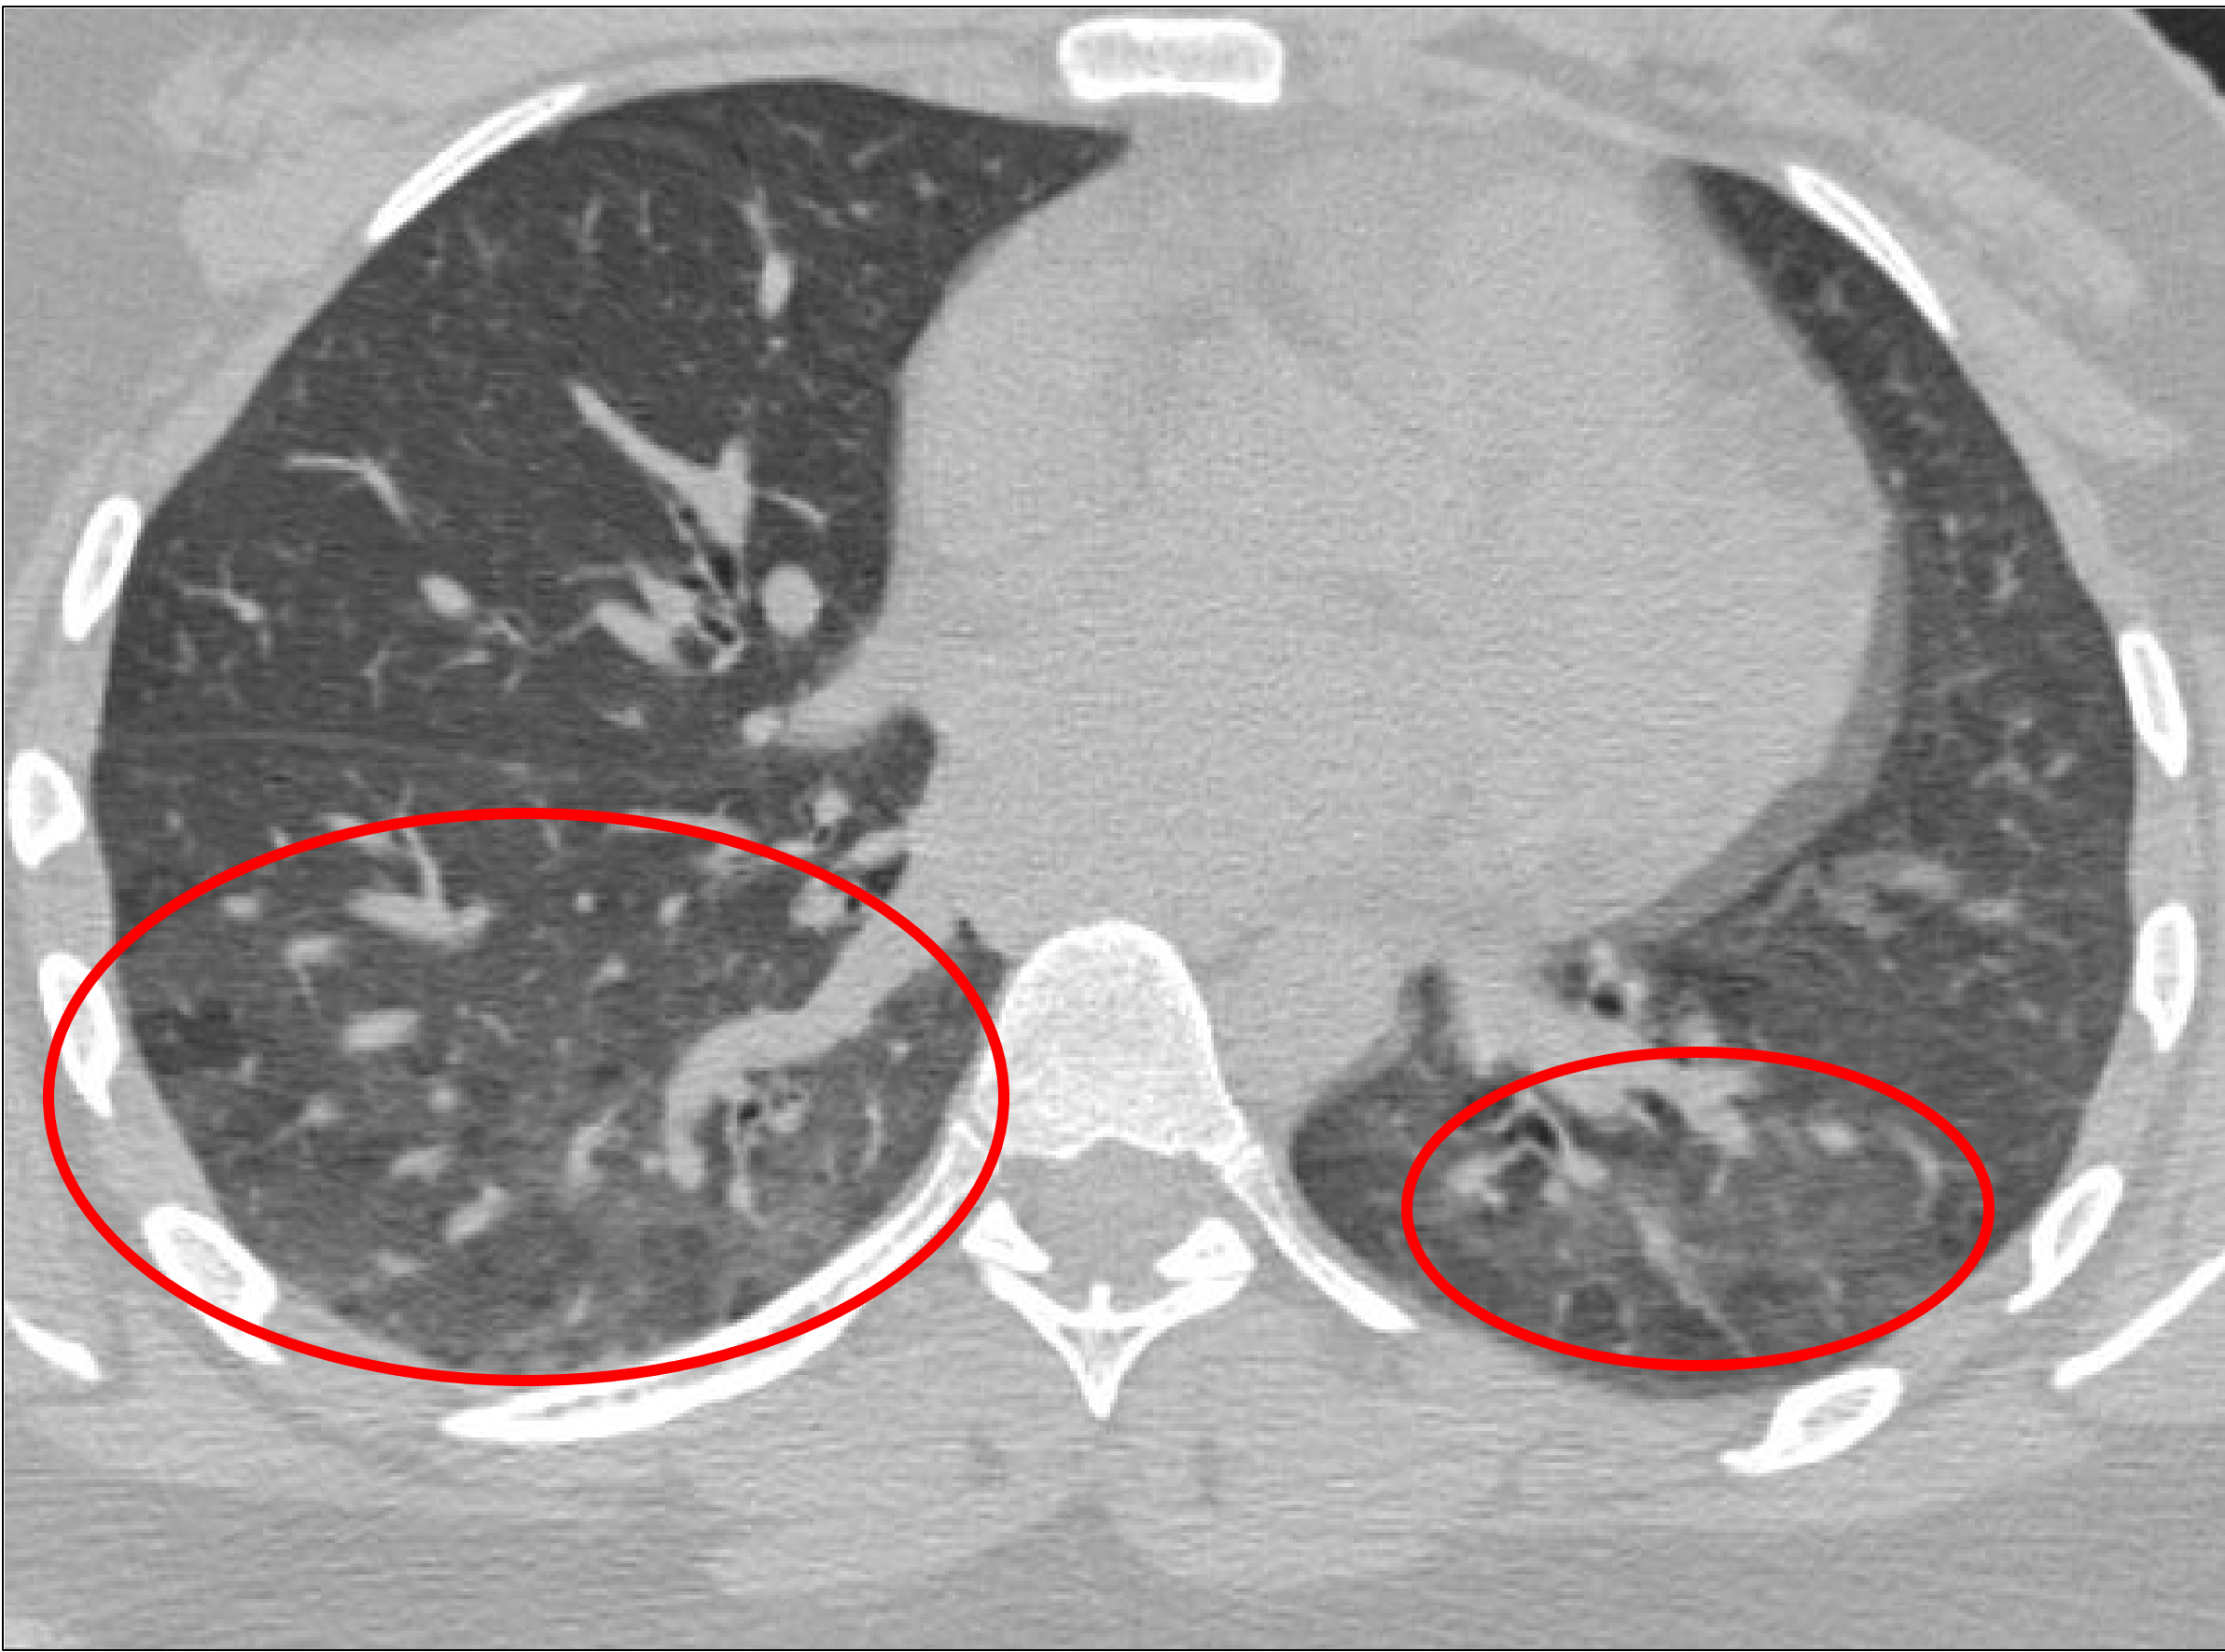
CT scan showing mild regions of air trapping in the bilateral lower lobes.
